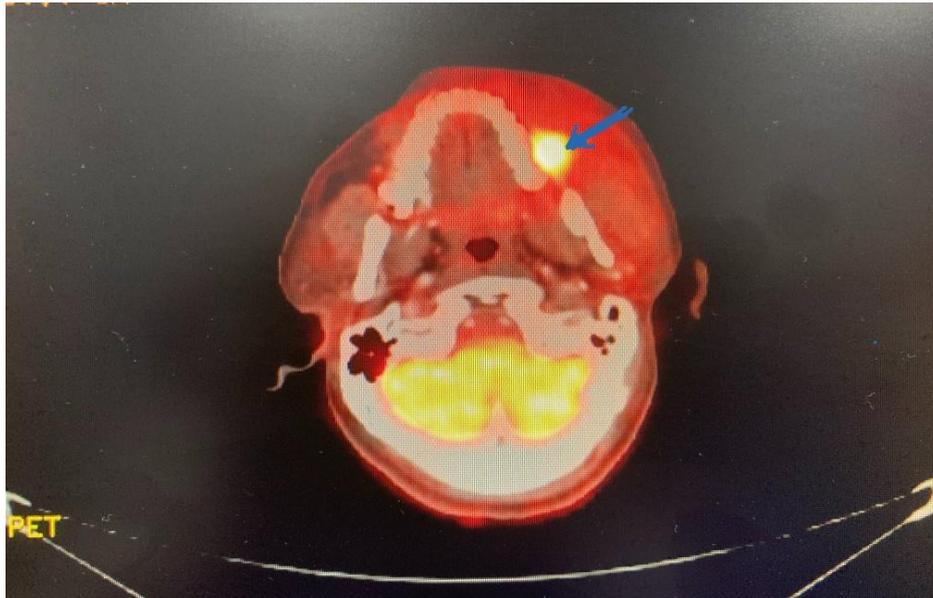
PET in early post operative period at 8 weeks showing high focal FDG uptake (SUV max 11.43) marked with arrow
